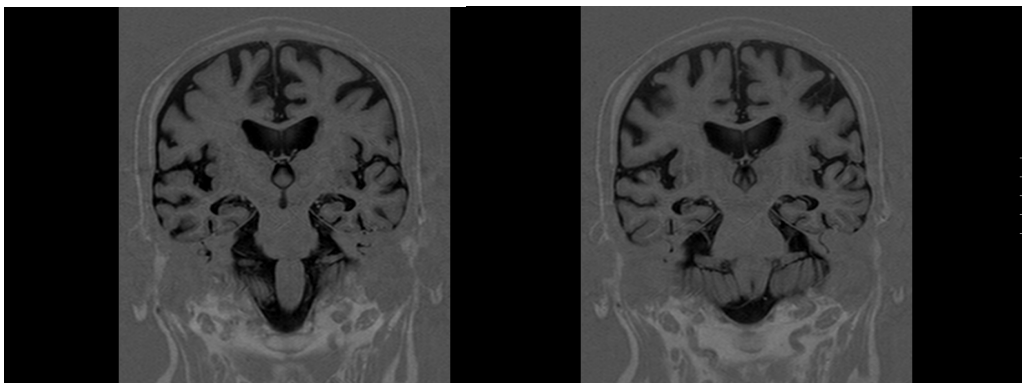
MRI scan (coronal T1) of PB's brain.
